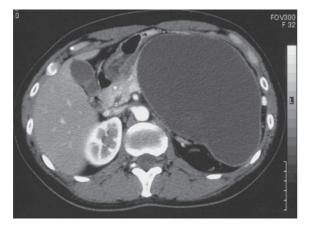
Computed tomography revealed a 17-cmdiameter cystic tumor that occupied almost the entire distal portion of the pancreas. No nodular lesion was observed in the cyst, and the tumor was diagnosed as a mucinous cystic neoplasm of the pancreas.
